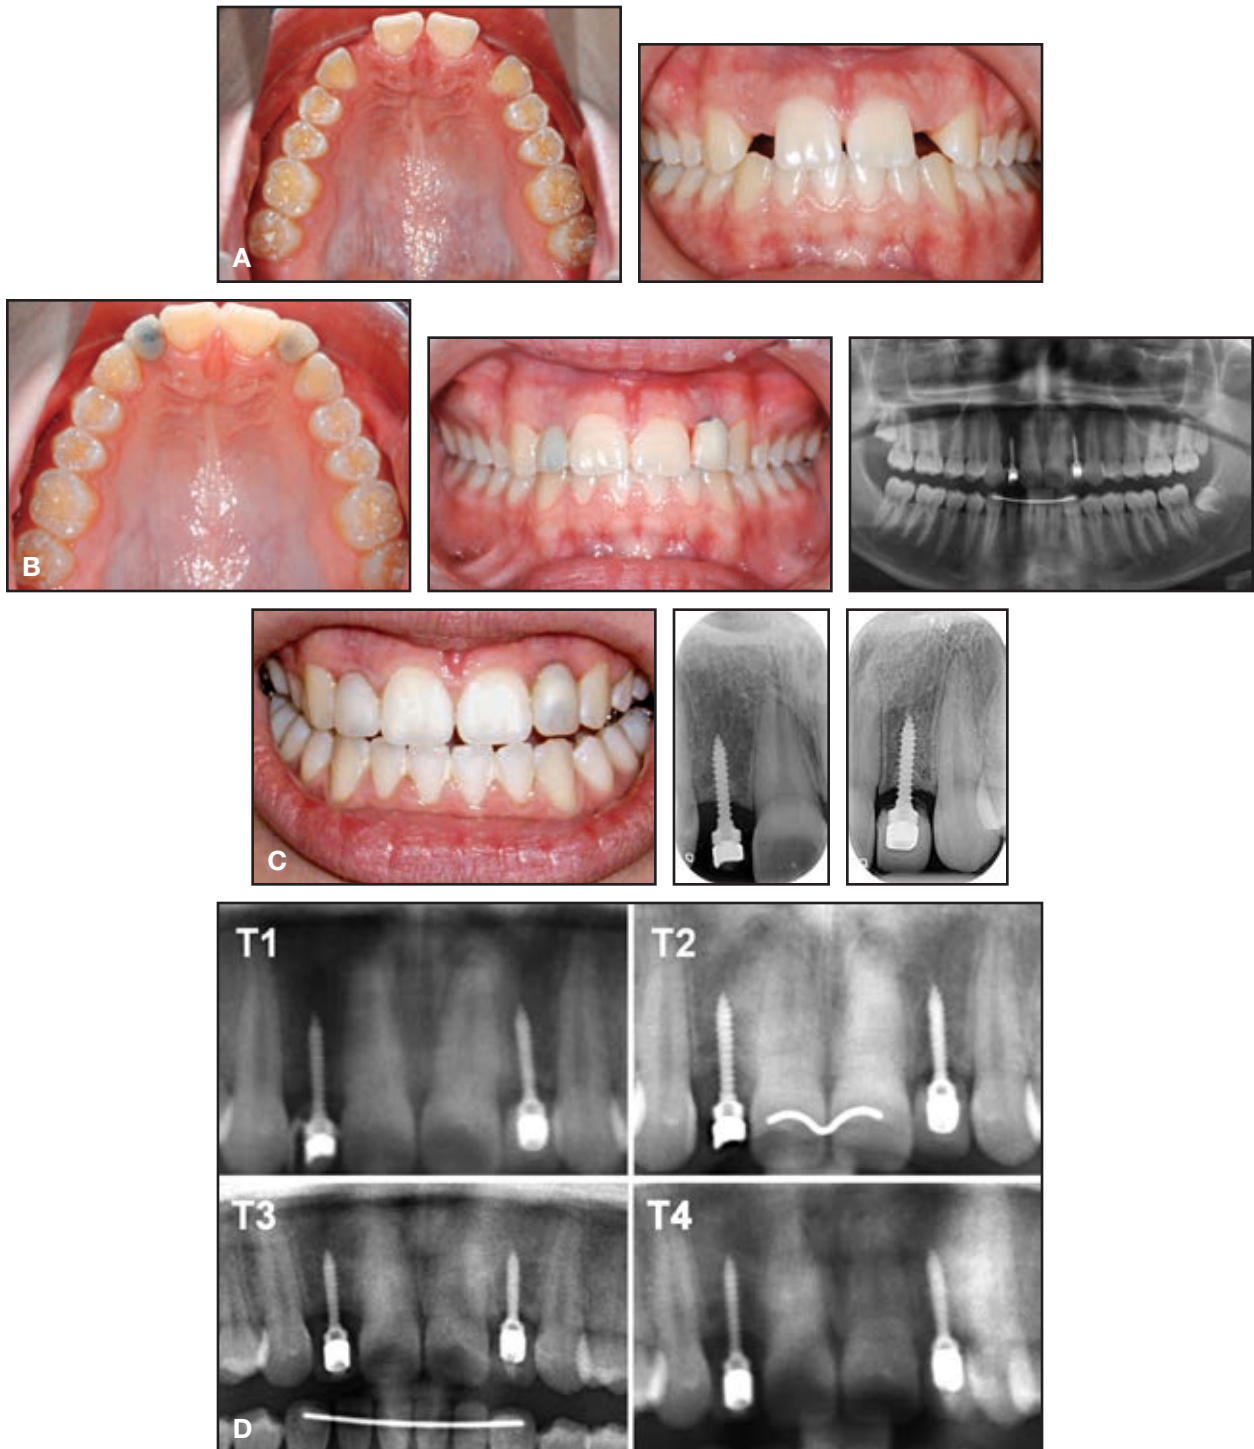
Case 2. A. 14-year-old female patient with missing upper lateral incisors after orthodontic space opening. B. Temporary pontics bonded over mini-implants (2mm × 11mm), with opaquer used on left crown. C. Four years later, crowns replaced using same mini-implants. D. Radiographs of upper incisor region taken immediately after (T1), two years after (T2), five years after (T3), and six years after (T4) insertion of mini-implants.
